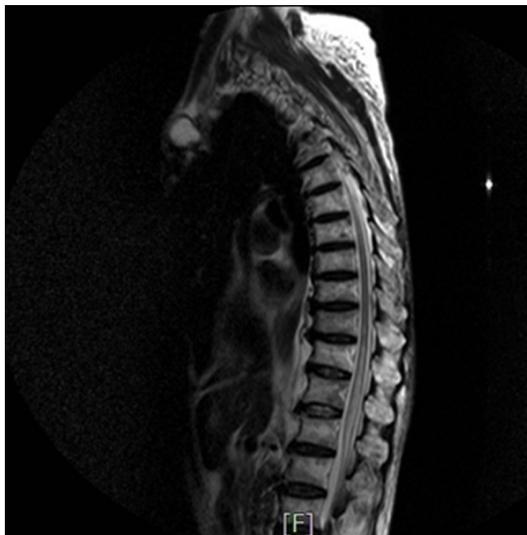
Magnetic resonance image showing spinal cord infarction at T10-L1 level.
